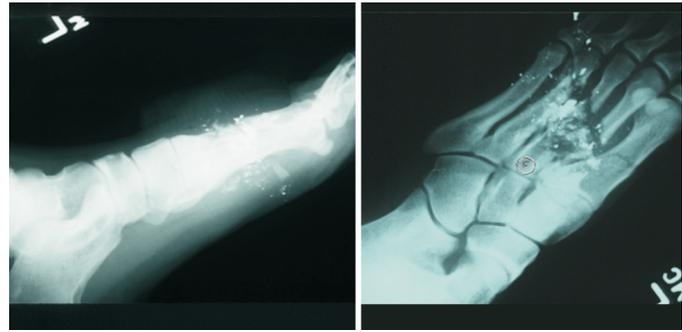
Radiographs of high-velocity projectile injury to the left foot.
